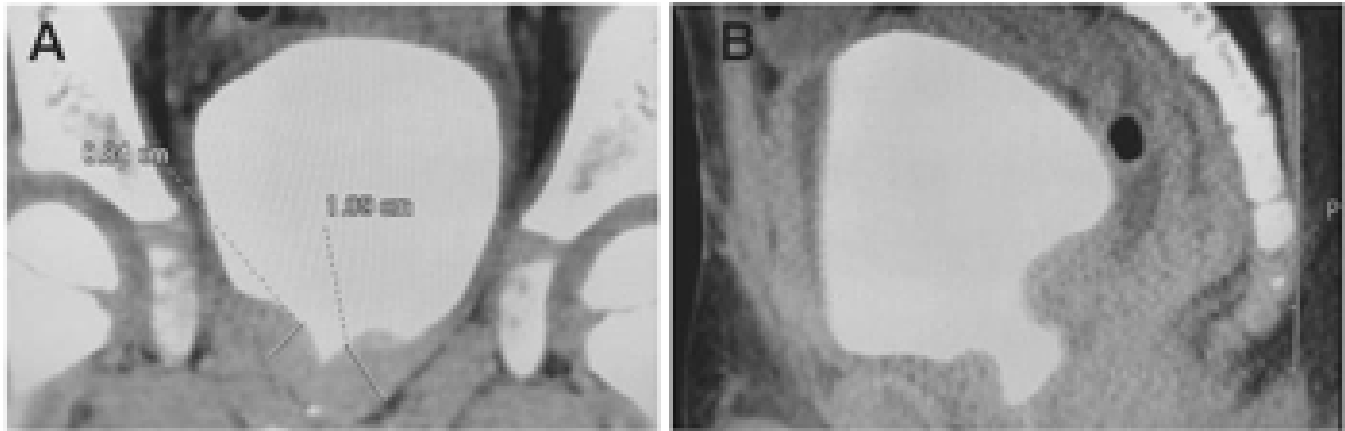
Bladder CT with contrast (November 2016). A (Coronal view) & B (Sagittal view). Showing no gross lesions noted on the urinary bladder.
